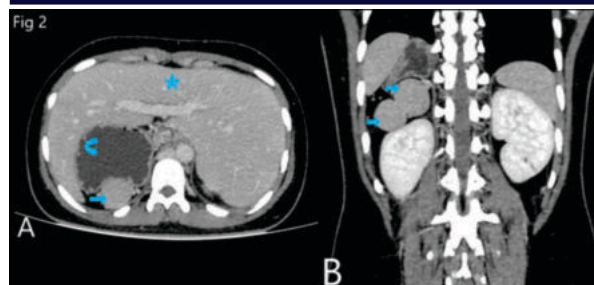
(A, B): Contrast-enhanced computed tomography (CECT) abdomen showing features of heterotaxy syndrome. A Axial section of CECT abdomen, portal venous phase showing midline liver (blue star) seen occupying right and left hypochondrium, stomach with hypodense content seen on the right side of midline (curved blue arrow) and splenunculus in the right hypochondrium (straight blue arrow). B Post-contrast, coronal reformatted image showing splenunculi (x2) in right upper quadrant (straight blue arrows).
